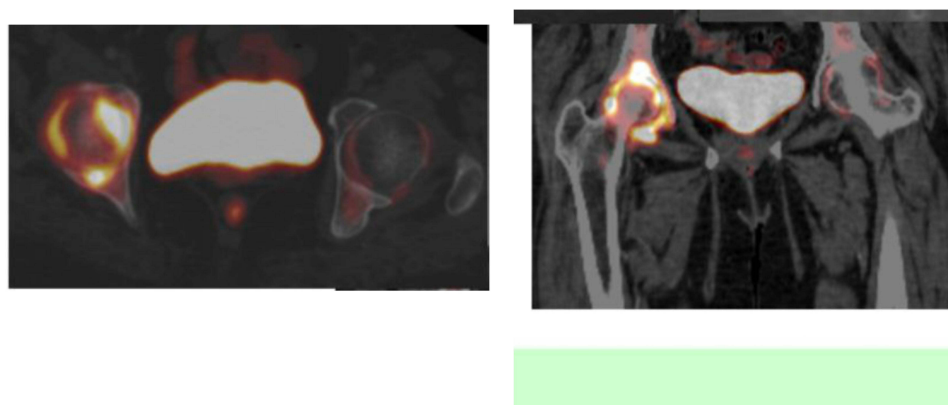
PET CT Scan of abdomen and pelvic showing right side Hip.
